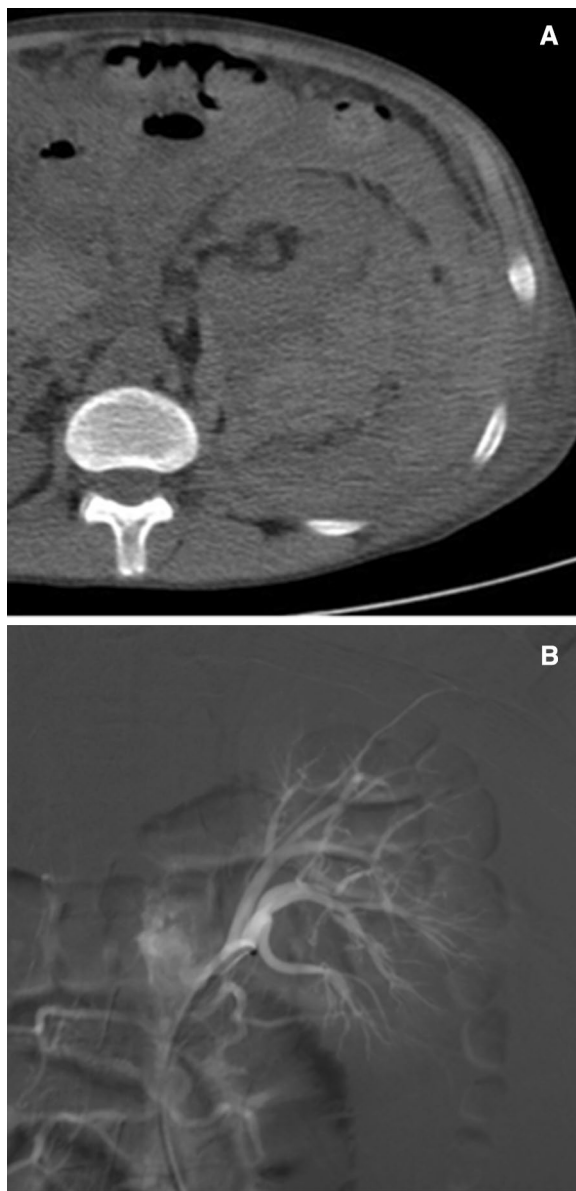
Axial non-contrast computed tomography imaging of a 42-year-old male patient with spontaneous haematuria showing a large posterior left perinephric haematoma displacing the kidney anteriorly (A). Selective left renal angiography of the same patient revealed normal intrarenal arteries with no vascular lesions (B)
